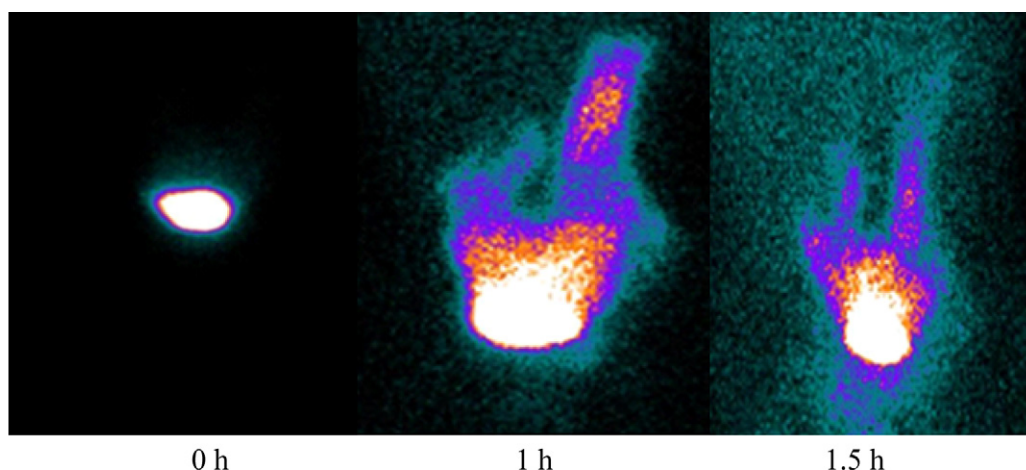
Gamma scintigraphic images of NFB in volunteer 1 after 0, 1, 1.5 h respectively.
